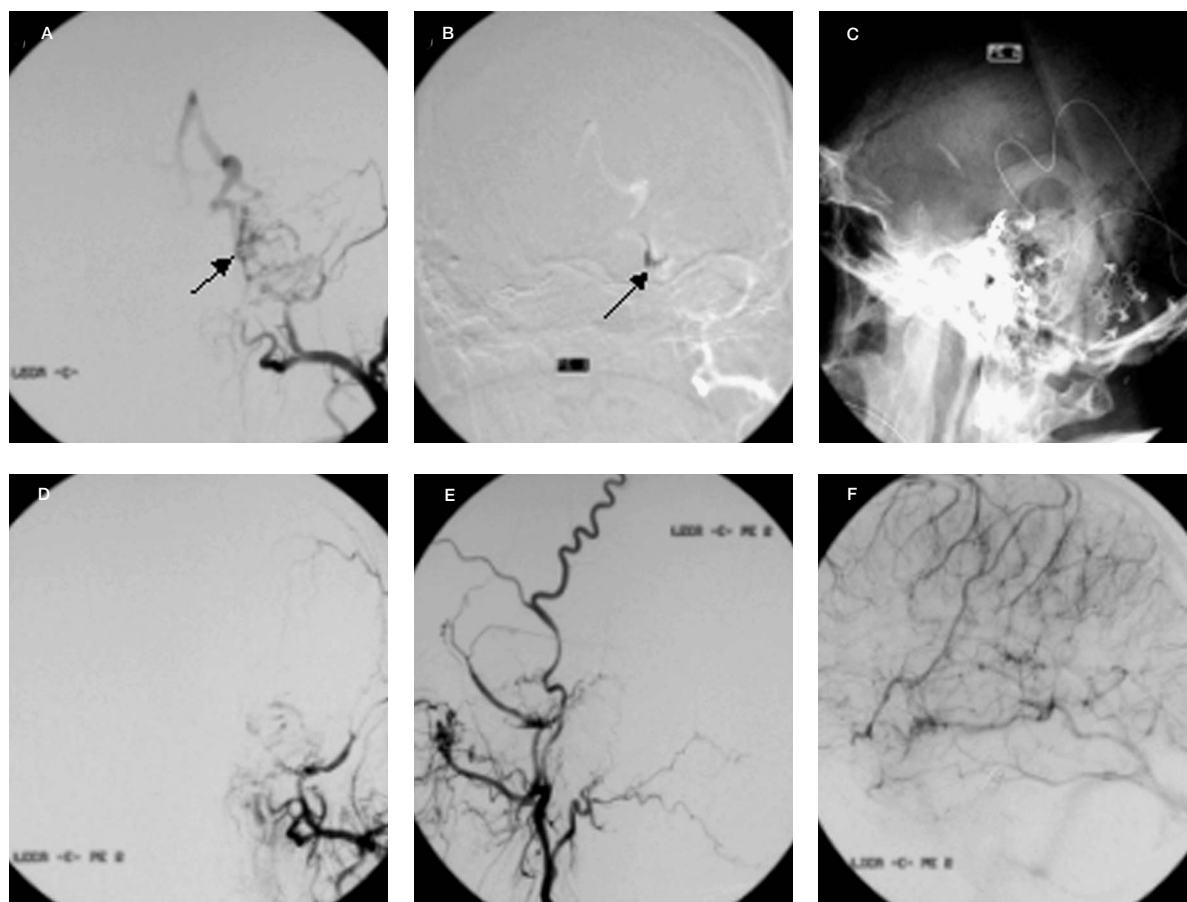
A) Left external carotid angiogram (AP view) before transvenous coil embolization shows recanalization of the previously embolized feeders from the middle meningeal artery. Note the site of AV fistula (arrow). B) Road map image shows coil loops cross the fistula (arrow). C) Plain film (lateral view) shows portion of a microcatheter via transjugular approach and coils prior to detachment. D,E) Post-embolization angiogram of the left external carotid trunk (AP and lateral view) shows complete occlusion of the dural AVM. Feeding pedicles decrease in caliber, and there is stagnation of the contrast. F) On the venous phase of the final angiogram of the left internal carotid artery, the basal vein of Rosenthal is now filling antegradely to the vein of Galen and straight sinus
